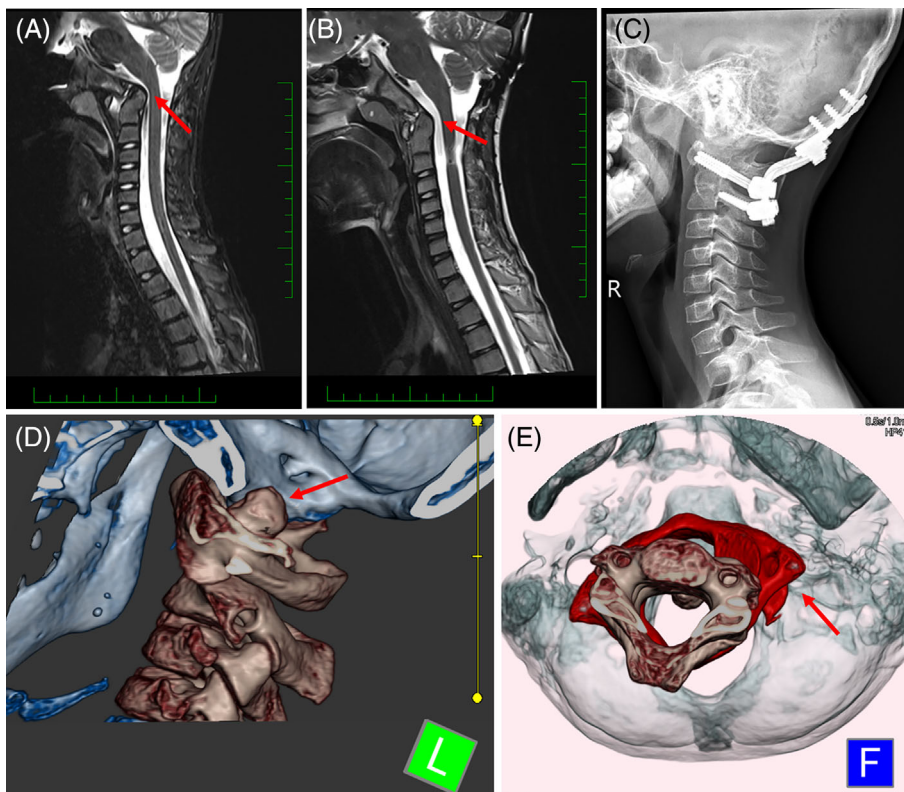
(A) Cervical spine magnetic resonance imaging (MRI) before treatment showing basilar invagination of the dens of the axis (red arrow). (B) Cervical spine MRI after the surgery, and a year into the biological treatment, MRI revealed a significant reduction in edema and a normal alignment of the C1-C2 joint, with no signs of dislocation (red arrow). (C) Surgical stabilization of the atlanto-occipital joint and the cervical spine. (D) Computed tomography (CT) scan before treatment revealing atlanto-axial rotatory dislocation of the atlas (red arrow). (E) CT reconstruction of the upper cervical spine before surgery demonstrating cranialization of the dens of the axis into the foramen magnum (red arrow).
